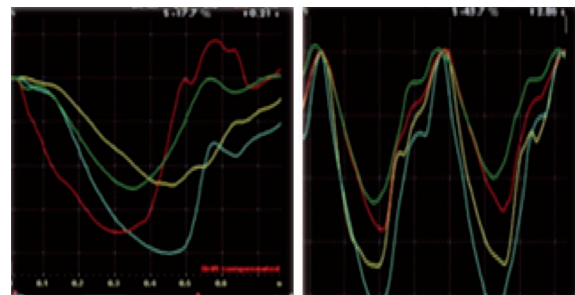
Tissue Doppler strain imaging: right ventricular desynchronization. Differences of time to peak systolic strain right ventricular free wall and septal segments after surgery (on the left) compared with normal subject.
